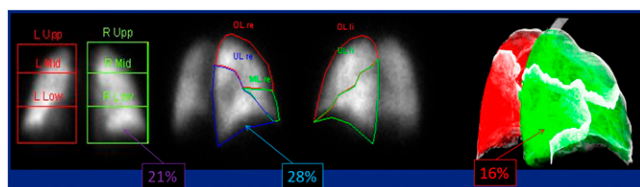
3D-quantitated lung perfusion $^{99\text{m}}\text{Tc}$ -MAA SPECT/CT and intended patient management in lung cancer. The authors compared the 2D projection method and their 3D quantitative method in assessing the lobar contribution to total lung perfusion and resulting management decisions. In this patient, the planar anterior/posterior (2D) method (left) resulted in 21% lobar perfusion, indicating high risk status and pointing to non-operable status. With the 3D quantitative method (right), lobar perfusion was 16%, and the patient was considered to be operable. 3D quantification had a major impact on intended surgical management in 14% of patients in the study.
